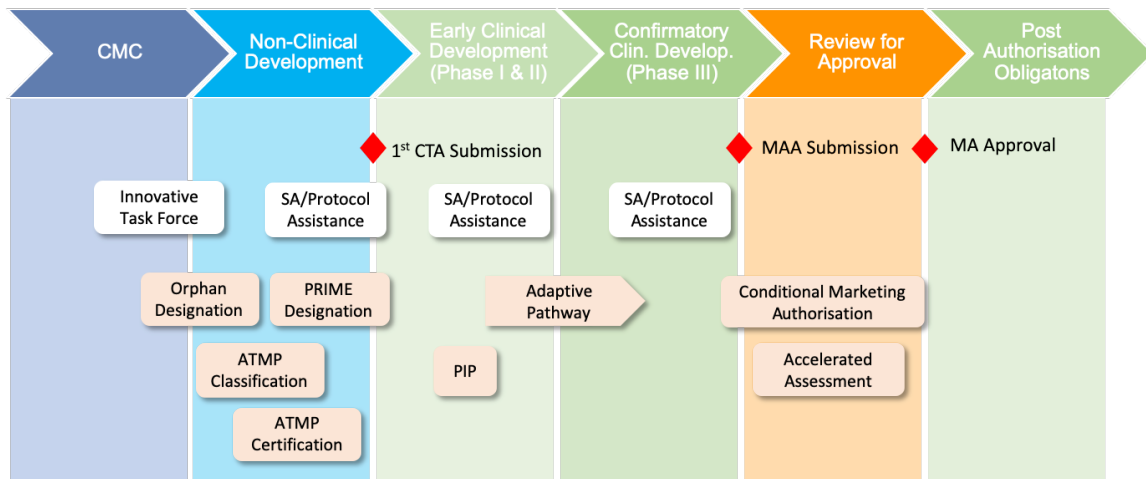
Regulatory strategy for CAR-T cell therapy in the EU. CTA: Clinical Trial Application, MAA: Marketing Authorisation Application, MA: Marketing Authorisation, SA: Scientific Advice, ATMP: Advanced Therapy Medicinal Product, PIP: Paediatric Investigational Plan.
